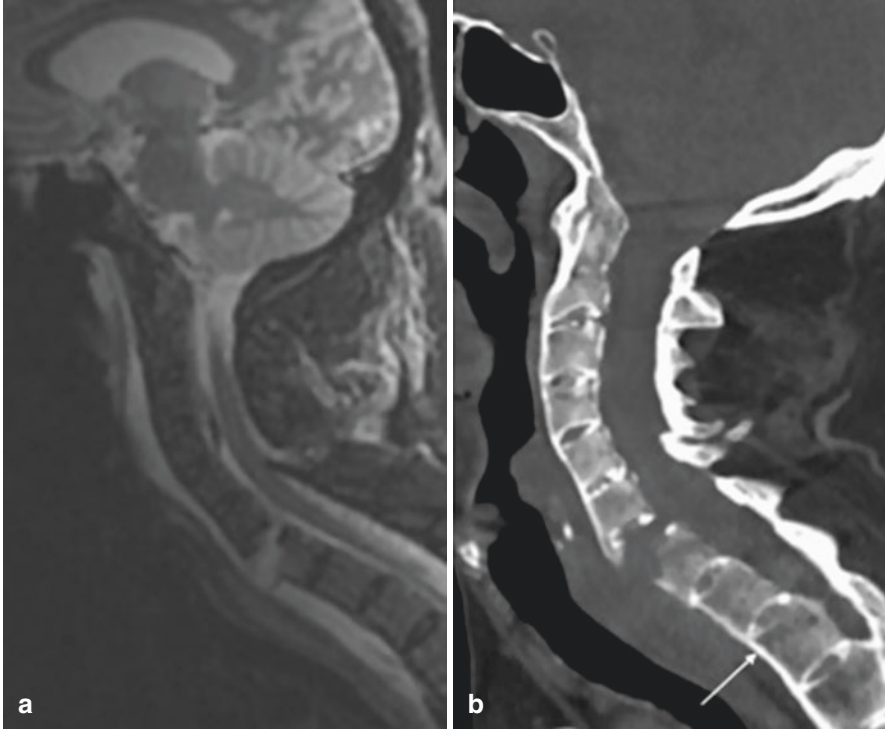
Magnetic resonance imaging (a) and computed tomography (b) of the fractured cervical spine of a 68-year old male with long-standing ankylosing spondylitis and Whiplash injury. A continuous line of intervertebral syndesmophytes (arrow) is representative of ‘bamboo’ spine
